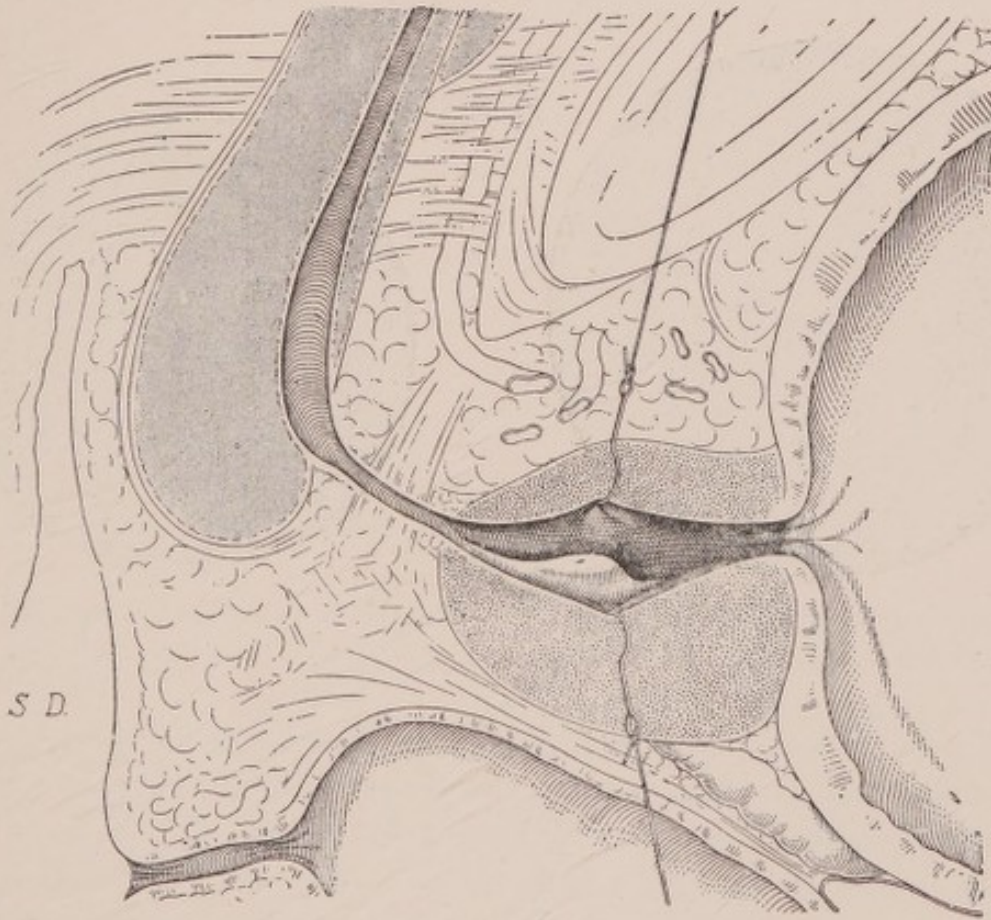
NORMAL ASPECT OF THE "PROSTATIC FOSSETTE" BETWEEN THE POSTERIOR END OF THE VERUMONTANUM AND THE NECK OF THE BLADDER.
